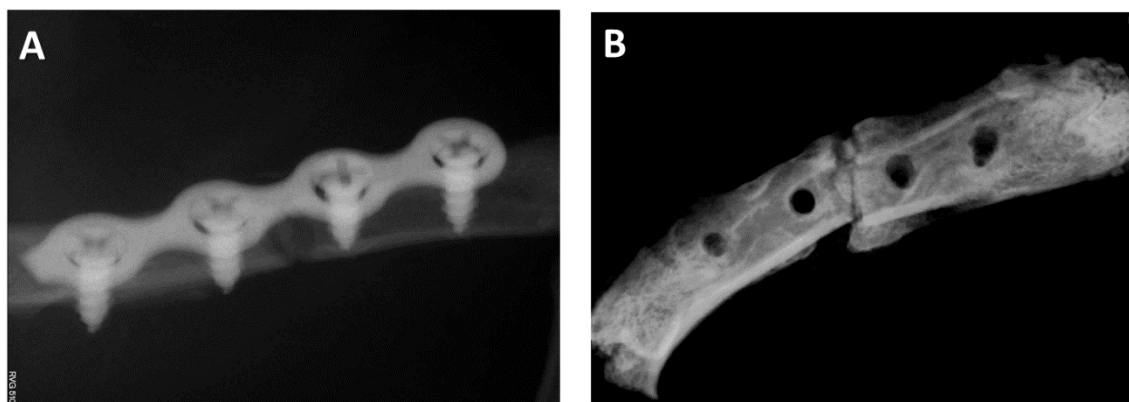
Postoperative radiographs: (A) seven days from the procedure; (B) 45 days from the procedure
